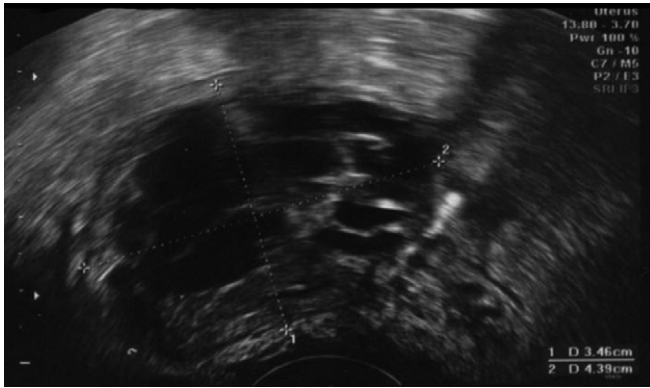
Ultrasonographic image of pelvic semi-solid mass.
